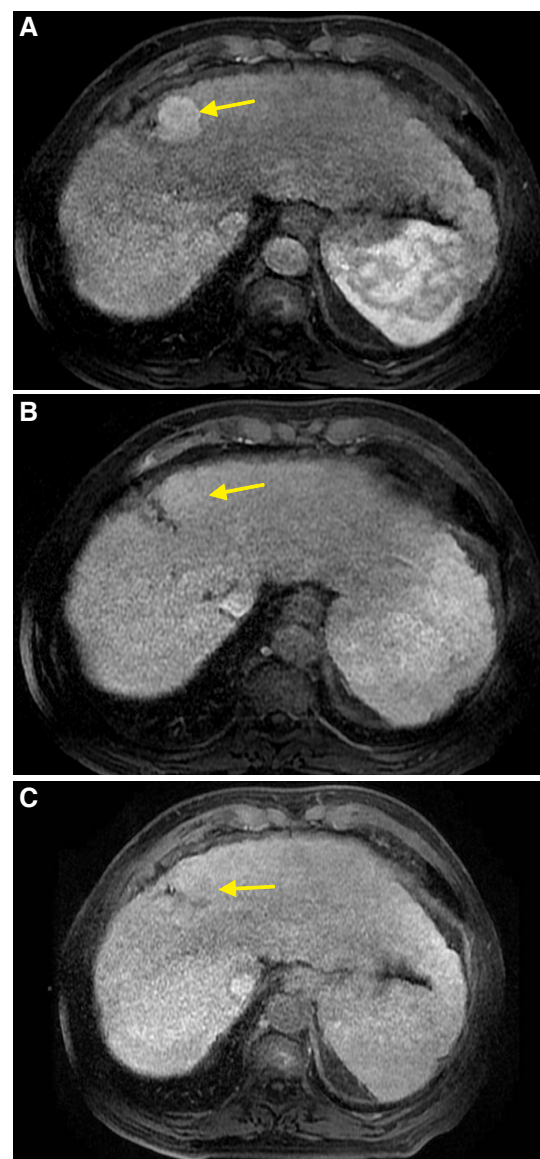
Magnetic resonance imaging. Liver acquisition with volume acceleration dynamic sequences obtained in axial planes at 6 min (A), 9 min (B), and 11 min (C). Enhancement of the lesion (arrow) in early stage (A) and washing (arrow) in the later stages (B and C) is observed
